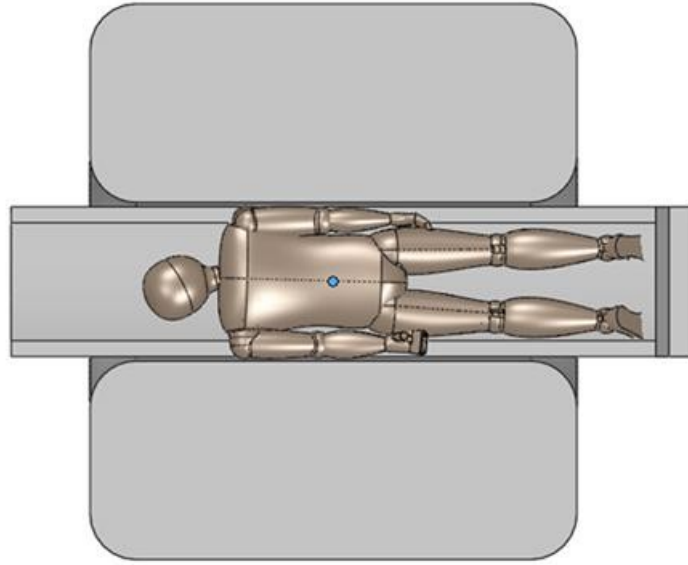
Working in closed-bore MRI scanners limits access to endoscopy patients. Sketch shows an average-sized patient with their abdomen at the scanner isocenter.
